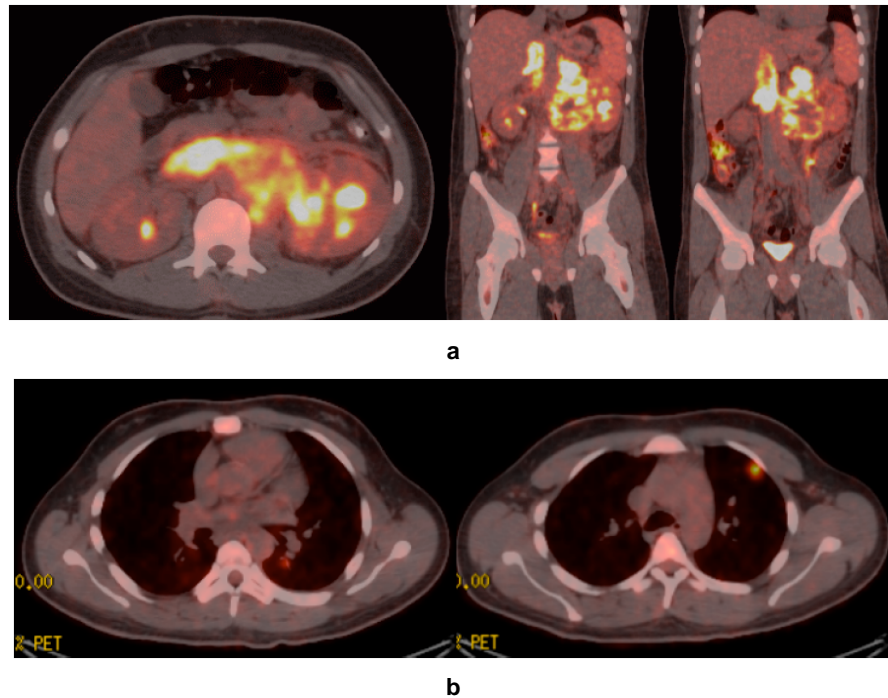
a and b F-18 FDG PET/CT.
